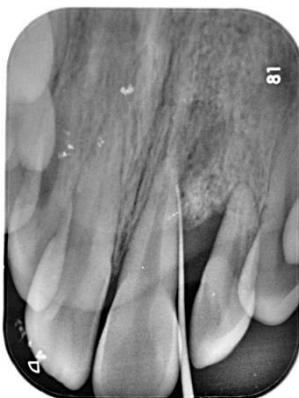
preoperative retro-alveolar radiograph with a gutta-percha cone inserted distally along the loss of attachment
